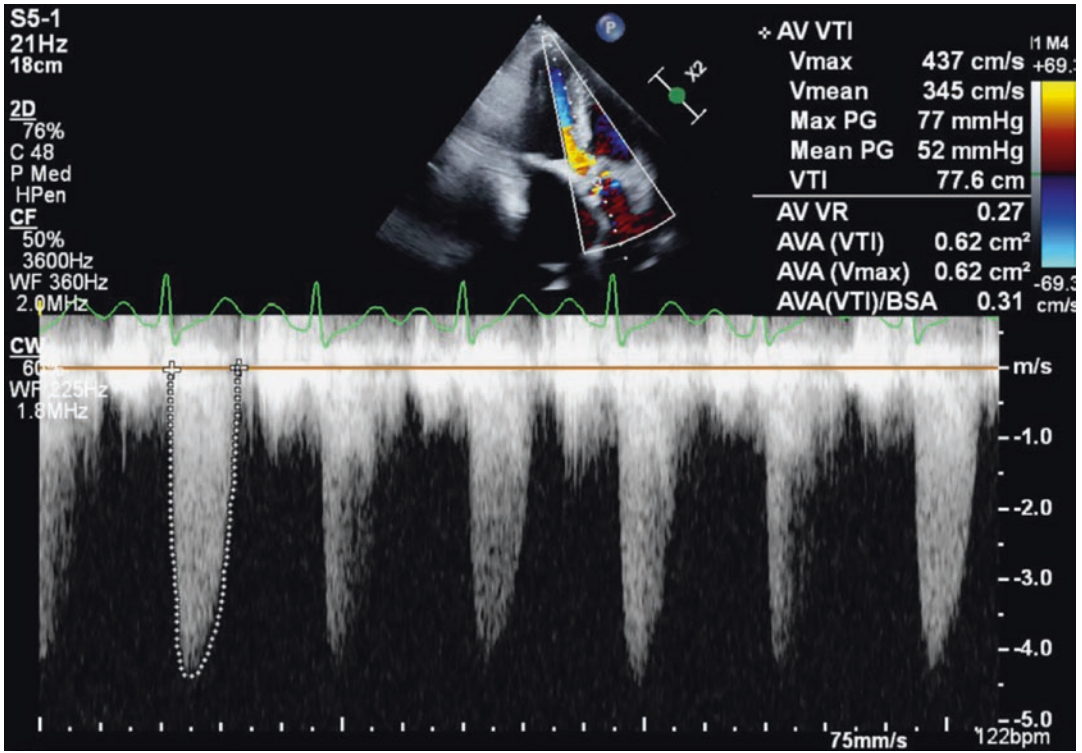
Doppler of severe Aortic Stenosis. Mean gradient 52 mmHg, Peak velocity max >4 cm/s and aortic valve area (AVA) 0.62 cm² suggestive of severe AS
